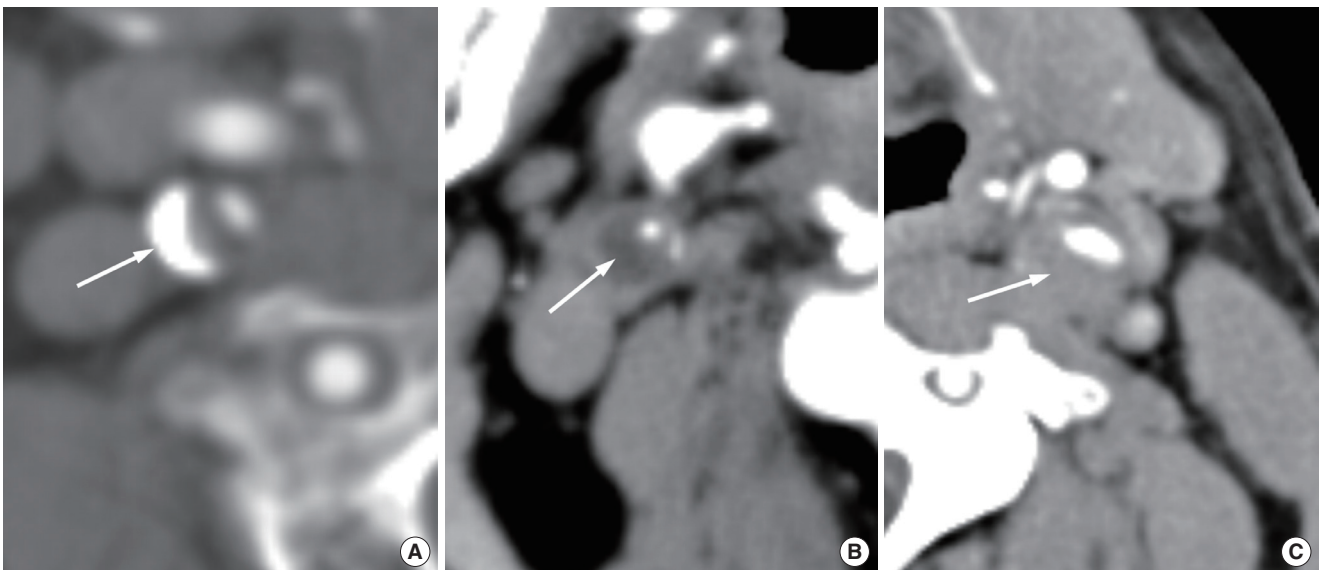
Different carotid plaques on computed tomography angiography. Arrow indicates (A) calcified, (B) fatty, and (C) mixed plaque.
